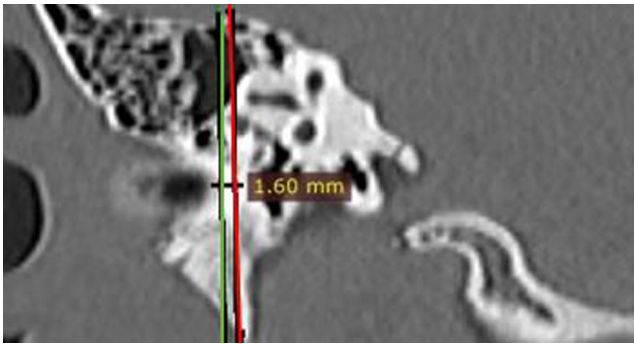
A coronal cut of right temporal bone HRCT, the right red vertical line passes through the lateral bony aspect of the LSCC, while the left green line passes through the lateral aspect of the mastoid segment of the facial nerve, indicating the lateral displacement of the facial nerve (it was scored 2 marks). HRCT, high-resolution CT scan.
